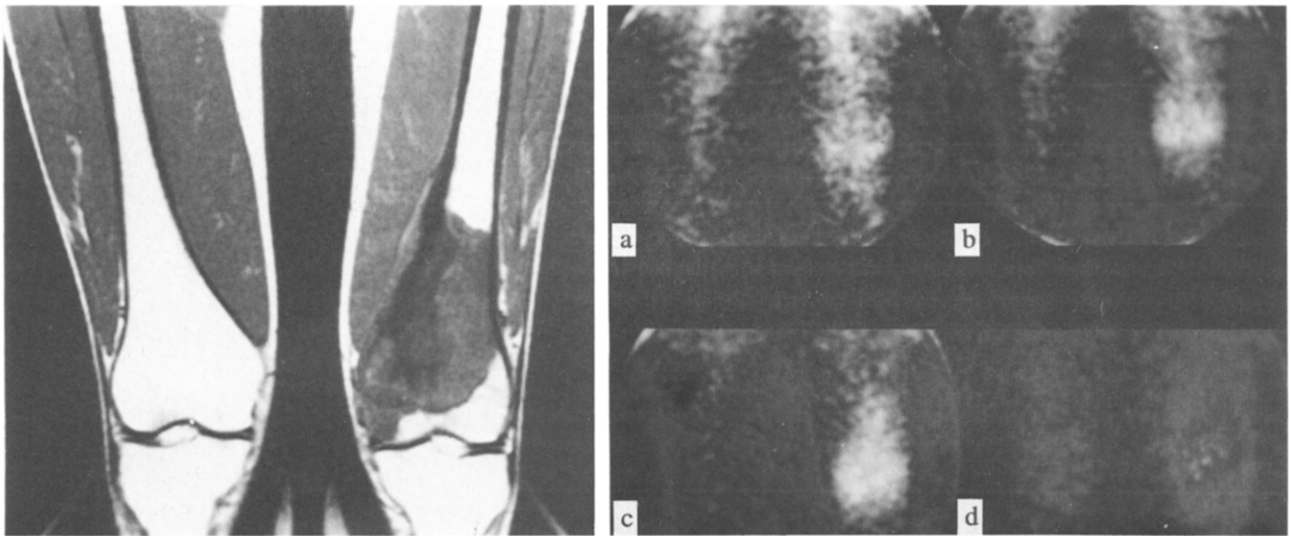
Immunoscintigraphy of patient 1 having a primary osteosarcoma in his left distal femur. Left: MRI scan. Right: immunoscintigraphy; planar images obtained at different time points (a:1, b:4, c:22 and d:52 h) after the injection of 0.8 mg TP-1 F(ab')₂ labelled with 90 MBq ¹³¹I.
